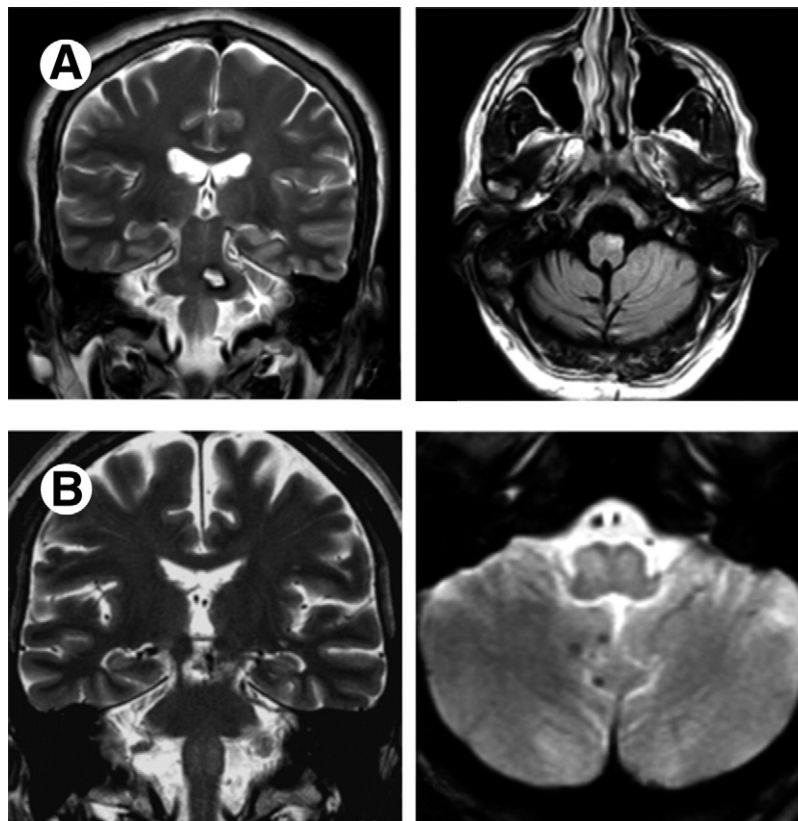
(A) Unilateral HOD. Coronal TSE-T2 (left) shows hyperintense focal lesion in the left ION. Note left pontine cavernoma, the primary midbrain lesion that led to ipsilateral HOD. Axial FLAIR (right) shows increased signal in left anterior medulla corresponding to the region of the ION. (B) Bilateral HOD. Coronal TSE T2-weighted image (left) shows bilateral hyperintensity confined to both IONs. Note mesencephalic AVM as primary midbrain lesion that led to bilateral HOD. Axial FFE-T2*-weighted image (right) shows a symmetric high signal bilaterally and enlargement of the IONs secondary to midbrain hemorrhage (not shown). Note 3 hypointense punctate foci in the right cerebellar hemisphere (multiple cavernomatosis).
